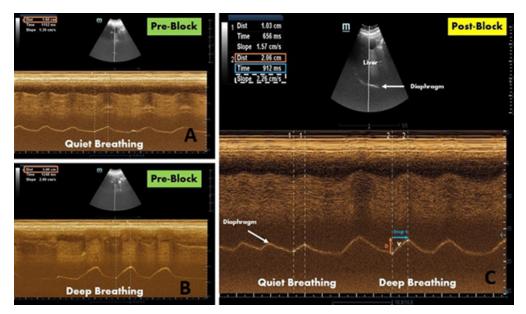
Ultrasound guided assessment of diaphragmatic excursion during quiet and deep breathing. Pre-block assessment of diaphragmatic excursion during quiet breathing. B) Pre-block assessment of diaphragmatic excursion during deep breathing. C) Post-block assessment of diaphragmatic excursion during quiet and deep breathing
